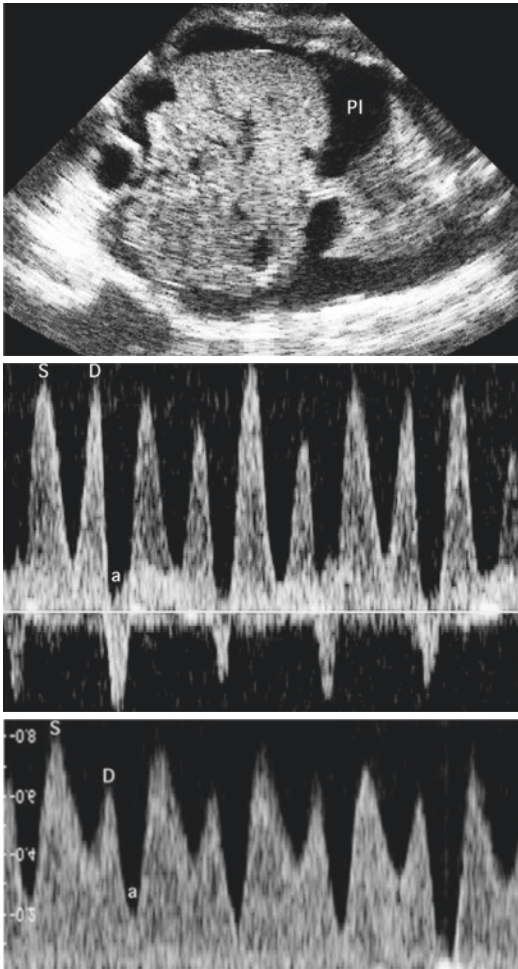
Effect of cardiac compliance on the venous waveform in the ductus venosus. Although a stiff myocardium due to acidosis or hypoxia is the most common cause, in this case it was the fetal pleural effusion (*PI*) at 30 weeks of gestation (*upper panel*) that had a constrictive effect on the heart. The reduced compliance was reflected in the rapid downstroke of the peak velocity during ventricular systole (*S*) causing the dissociation between *S* and the diastolic peak (*D*; *middle panel*). Doppler recording 2 min after the pleural effusion had been drained off (*lower panel*) showed an instantaneous improvement in myocardial compliance (less pointed *S* and reduced dissociation between *S* and *D*), and the end-diastolic pressure was less, signified by the less pronounced atrial contraction wave (*a*)
